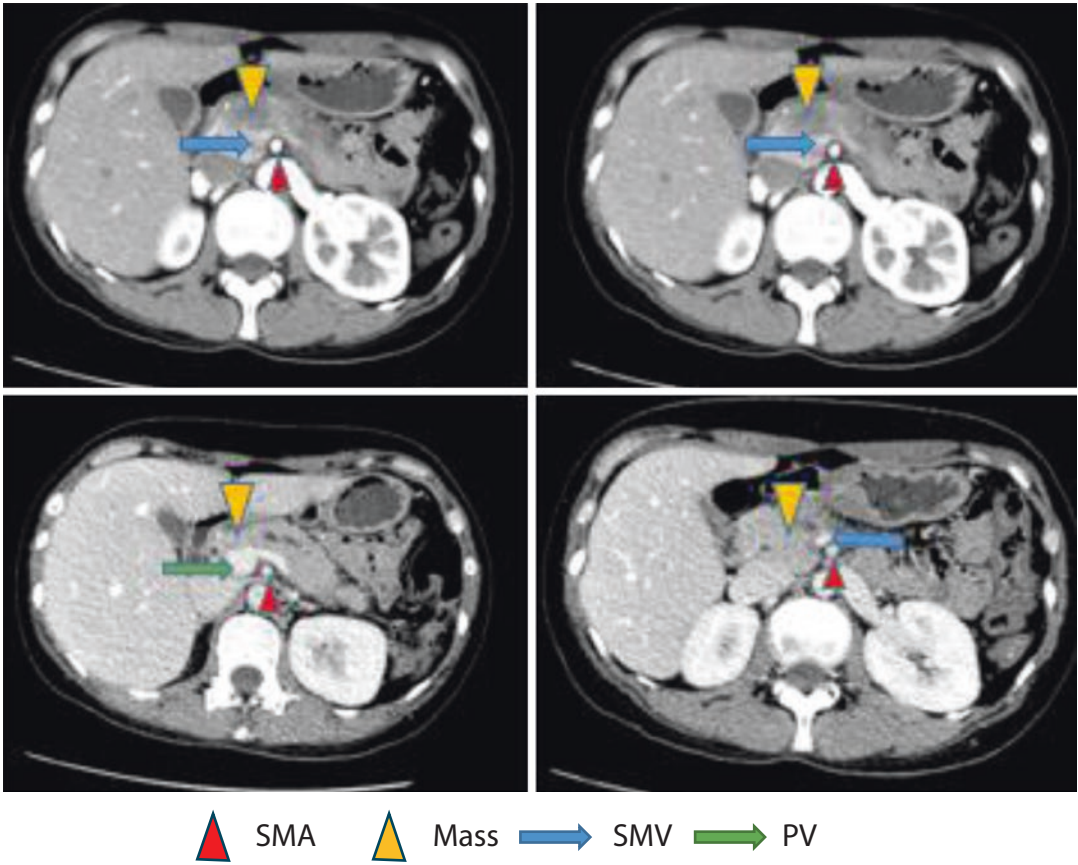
CT scan showed pancreas head carcinoma invaded SMV and PV
